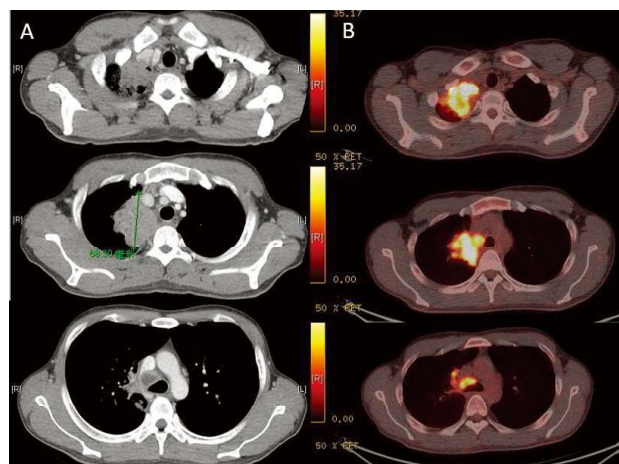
(A) CT revealed a 6.8 cm x 5.5 cm soft tissue mass at the upper lobe of the right lung, which abutted the mediastinum, and necrotic lymph node at the right paratracheal space. (B) PET revealed a mass at the apex of the right upper lung and right mediastinal lymphadenopathy, with a maximum standardized uptake value (SUVmax) of 18.0 and 10.3, respectively.
